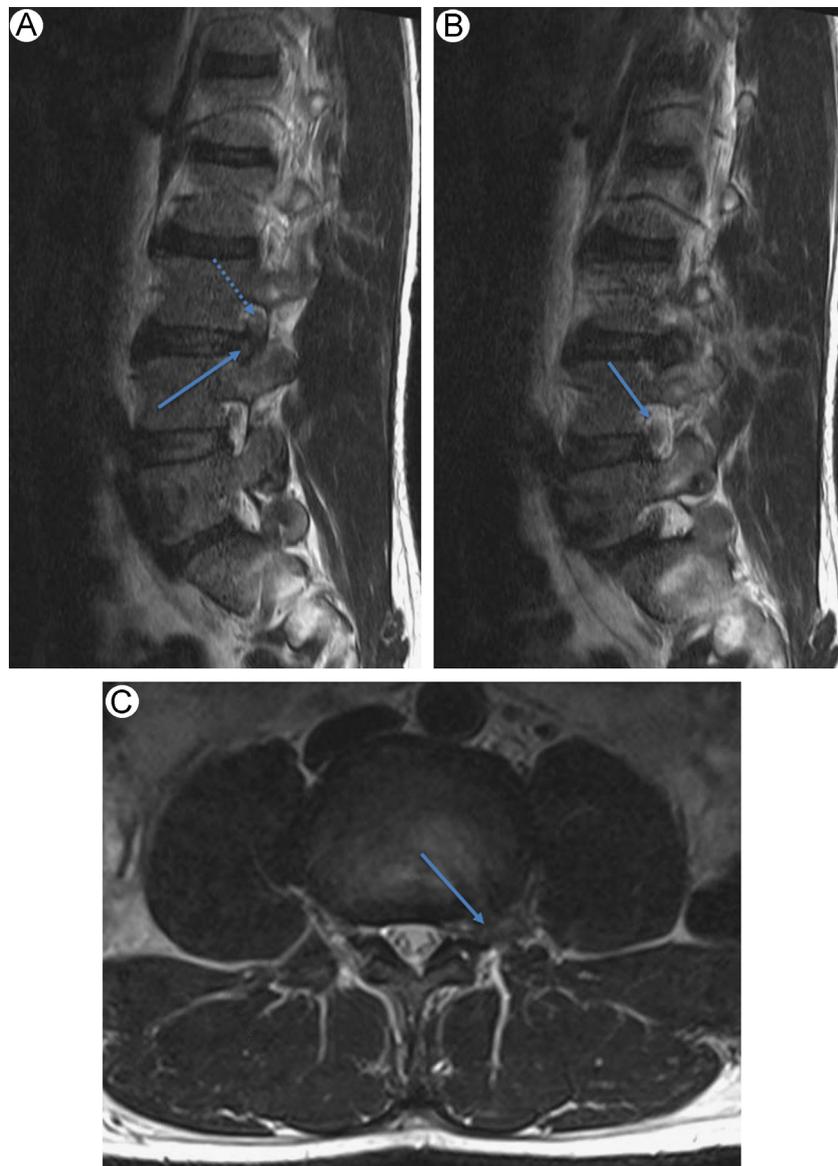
Left far lateral herniation at L3-4 on sagittal and axial T2-weighted MRI. (A) The left parasagittal image demonstrates the herniated disc (solid arrow) compressing the exiting L3 nerve (dashed arrow). (B) A more lateral left parasagittal images shows the L4 nerve root (arrow) in the L4-5 foramen completely free, whereas the L3-4 disc herniation is obliterating the foraminal space. (C) On this axial cut, the blue arrow demonstrates the left lateral herniation.
